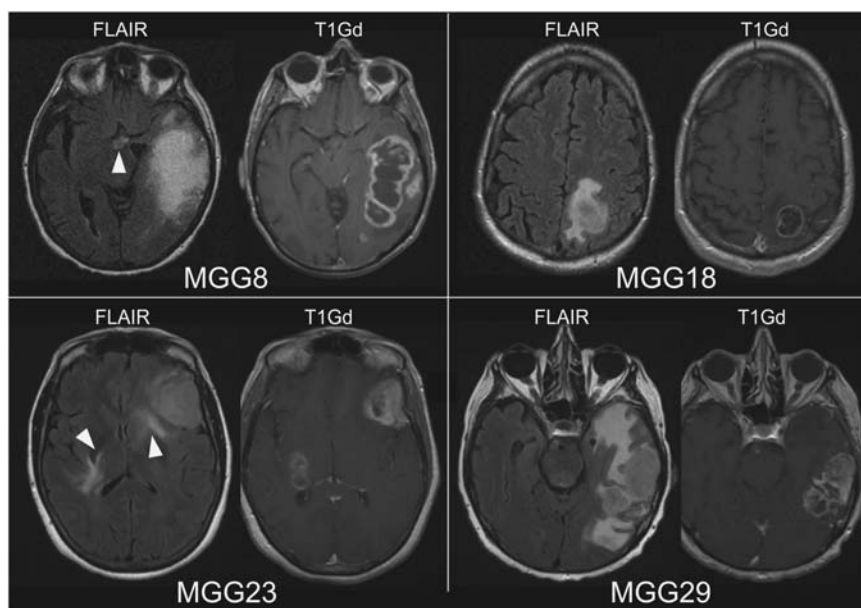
Patient preoperative MRIs. MR images taken before surgeries showing MGG8 and MGG23 that produced GSCs of highly invasive phenotype, and MGG18 and MGG29, from which GSCs of discrete nodular phenotype were derived. Arrowheads show hyperintense abnormal lesions in FLAIR images at the midline or bilateral regions suggestive of tumor infiltration. T1Gd, T1 images after infusion of gadolinium contrast agent.
